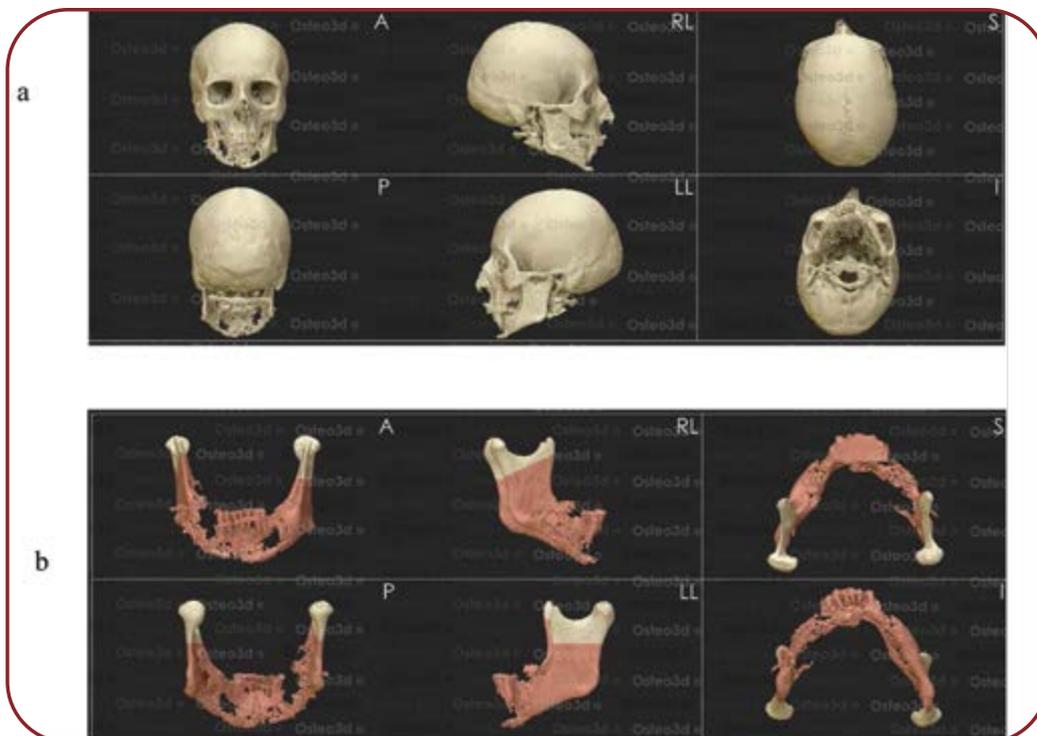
Tumor involving the mandible: a) skull reconstruction using high resolution CT images; b) mandible reconstruction using high resolution CT images
